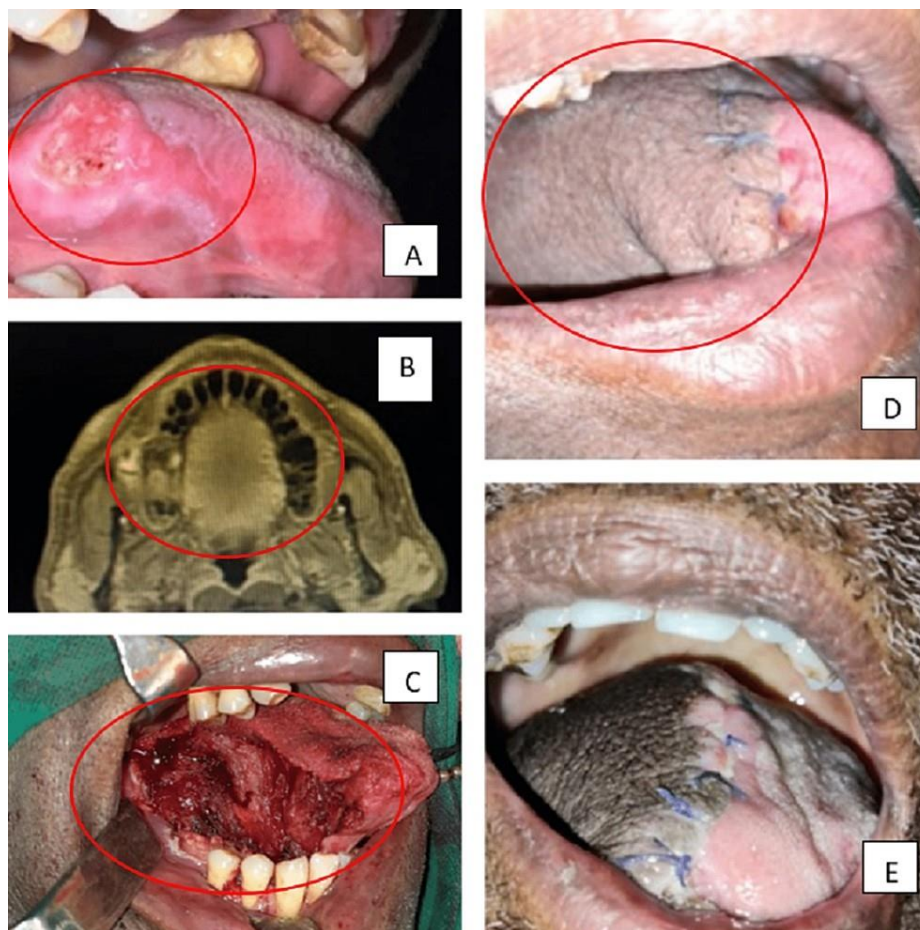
Showing clinical photo of lesion, radiological investigation (MRI), surgical defect of tongue, primary closure and follow up photograph (A: Ulceroproliferative lesion present over lateral border of tongue, B: MRI tongue showing extension of lesion, C: Defect created after resection of lesion i.e., Partial Glossectomy, D: Primary Closure, E: 6 months follow up photo)
